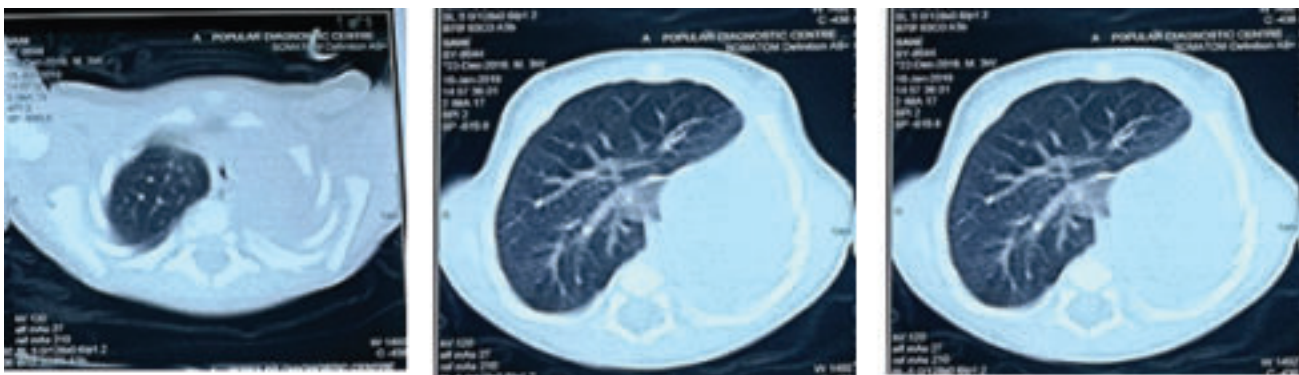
CT scan of the chest
